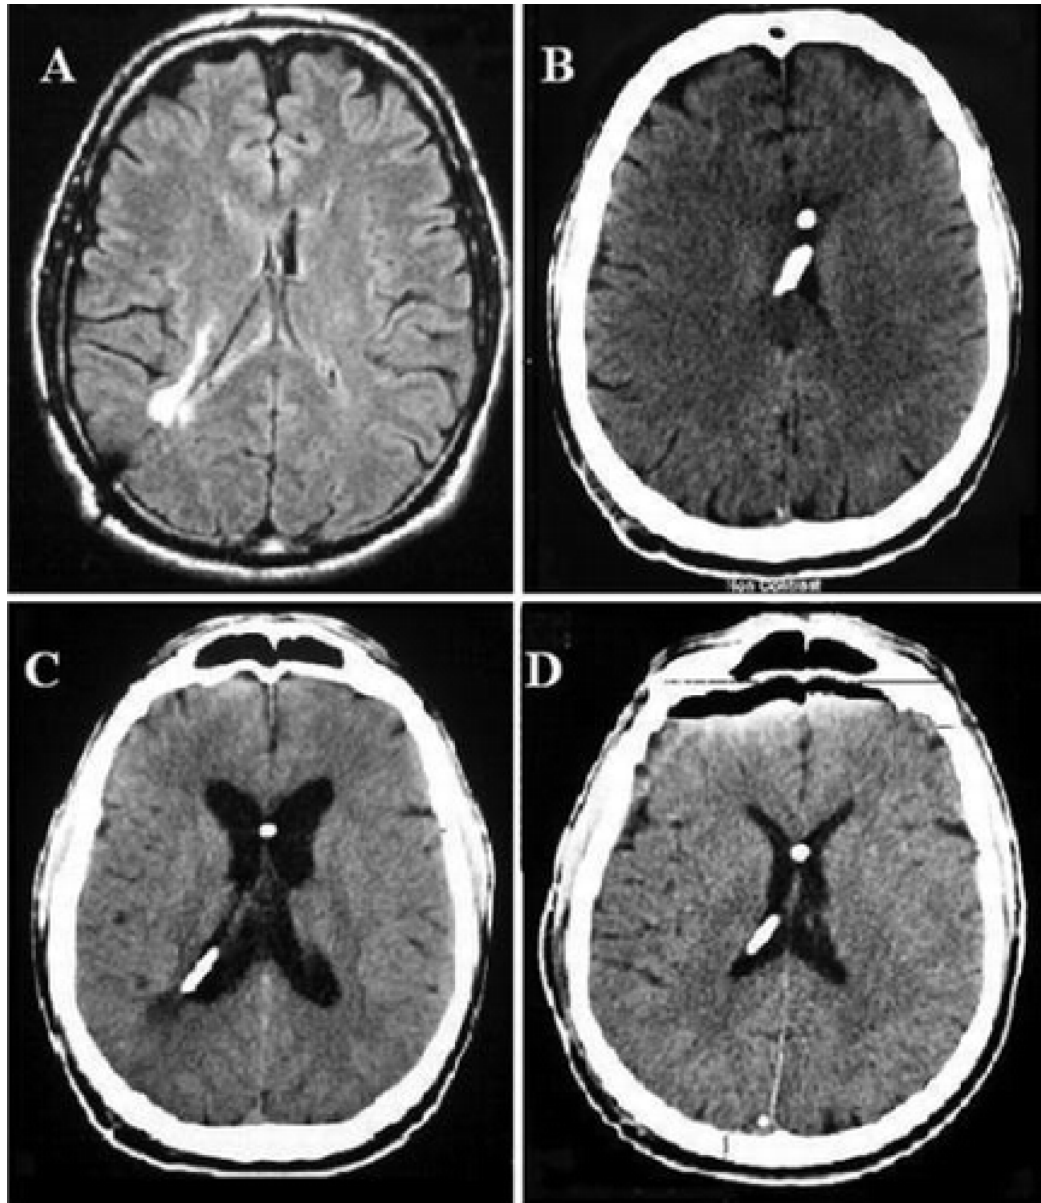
MRI scans of a 53-year-old male patient with alternating slit and dilated ventricles: (a) showing slit ventricles on presentation that did not change on CT (b) after the shunt was reset to 150 mm H₂O, but showed dilation on CT (c) with only a 10 mm H₂O increase in opening pressure to 160 mm H₂O. The slit ventricles returned to normal size on CT (d) after the third ventriculostomy procedure (Maroulis et al., 2008).
